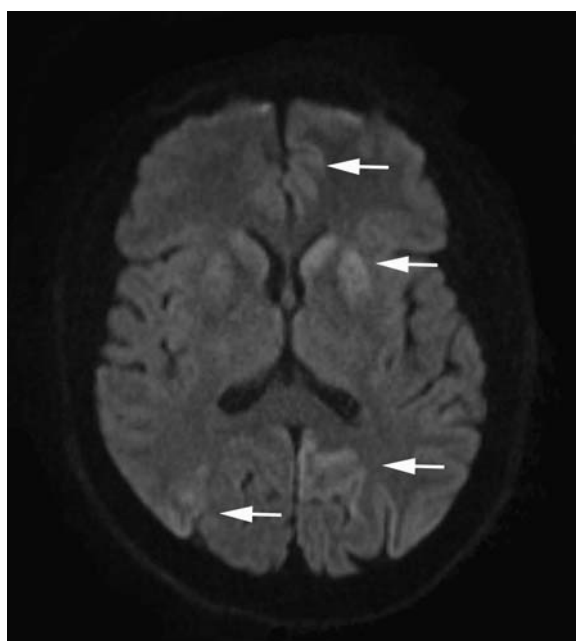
Diffusion-weighted magnetic resonance imaging. Shown is a single, representative axial image with areas of restricted diffusion (white arrows), consistent with Creutzfeldt-Jacob disease.
